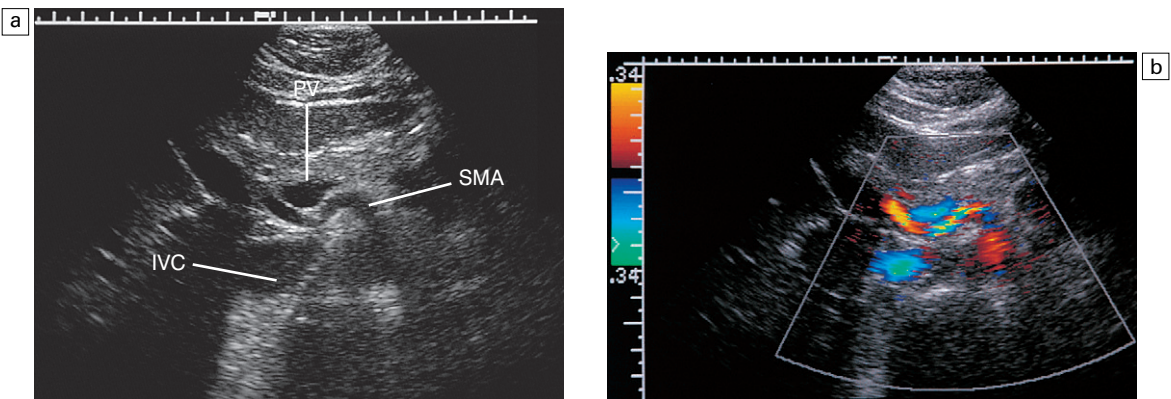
(a) Transverse image of the mid-abdomen at the level of the superior mesenteric artery origin. A tubular structure is seen coursing from the superior mesenteric artery (SMA) to the right lobe of the liver, between portal vein (PV) and the inferior vena cava (IVC). (b) Colour Doppler identifies this tubular structure as a vessel. An arterial signal on spectral Doppler, identification of its SMA origin and a course towards the right lobe of the liver confirm this to be a replaced right hepatic artery.
